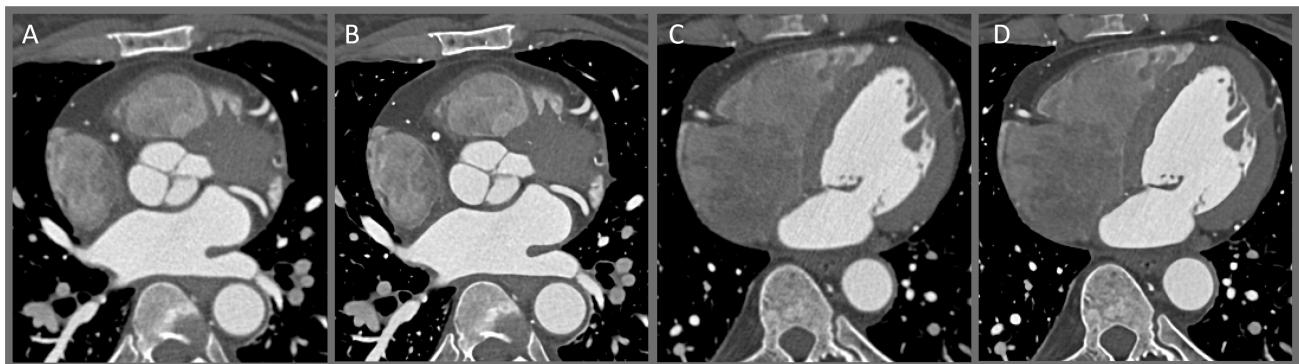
Exemplary axial images from a gated cardiac CT acquisition shown at two different axial slice locations of the human heart. A and B depict the same axial cross section with the conventional cardiac reconstruction shown in A compared to the DL-based image de-blurring method shown in B. Both images are windowed to a level of 200 HU and a window width of 1250 HU. C and D show a lower axial slice. Again, conventional processing in C is compared to the processing with DL image de-blurring active as shown in D. Here both images are shown at a level of 250 HU and with a window width of 1200 HU.
